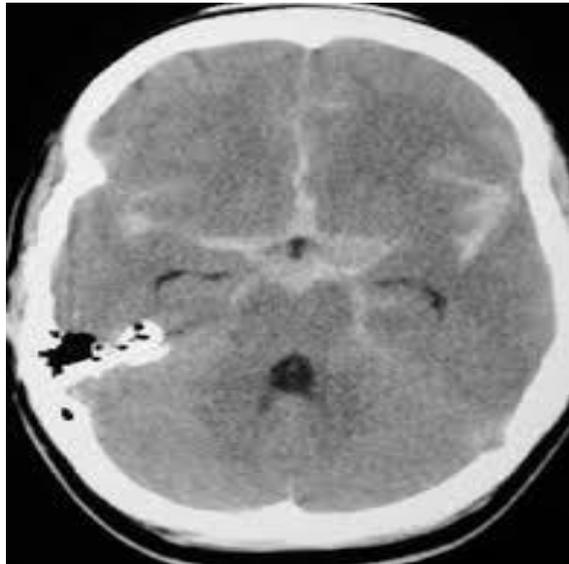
CT Scan Brain Showing Sub Arachnoid haemorrhage
